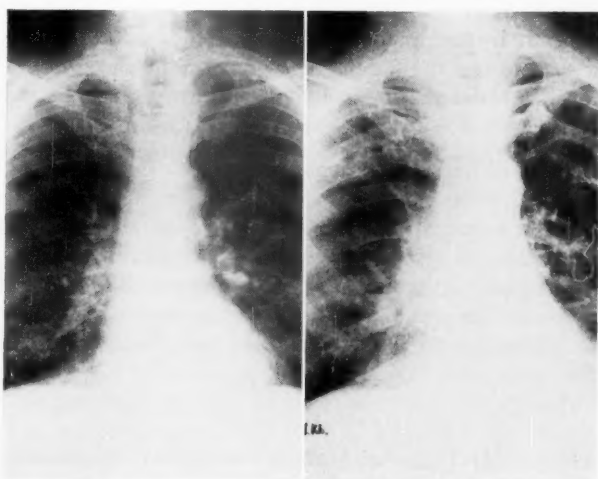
H. K. a. Pre-operative chest x-ray. b. Postoperative chest x-ray.
